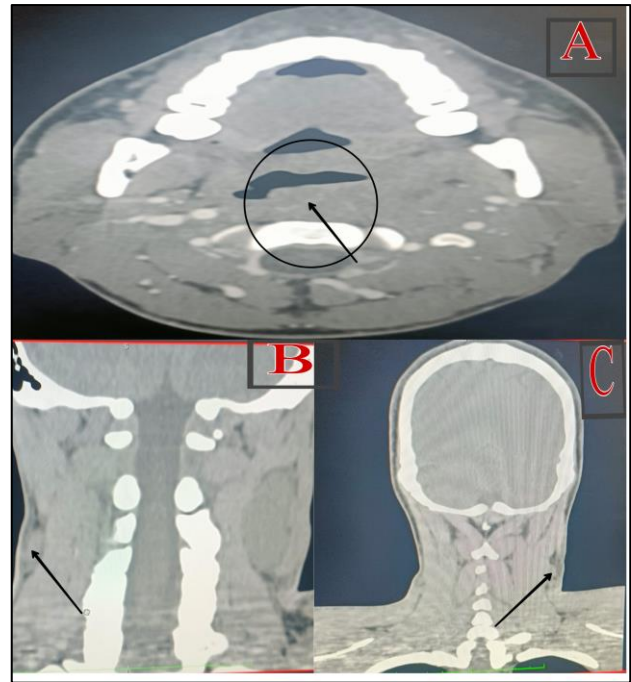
(A-C): Contrast enhanced CT of neck with PNS of homogeneous mass lesion epi-centered in pharyngeal mucosal space with retropharyngeal and bilateral cervical lymphadenopathy.
